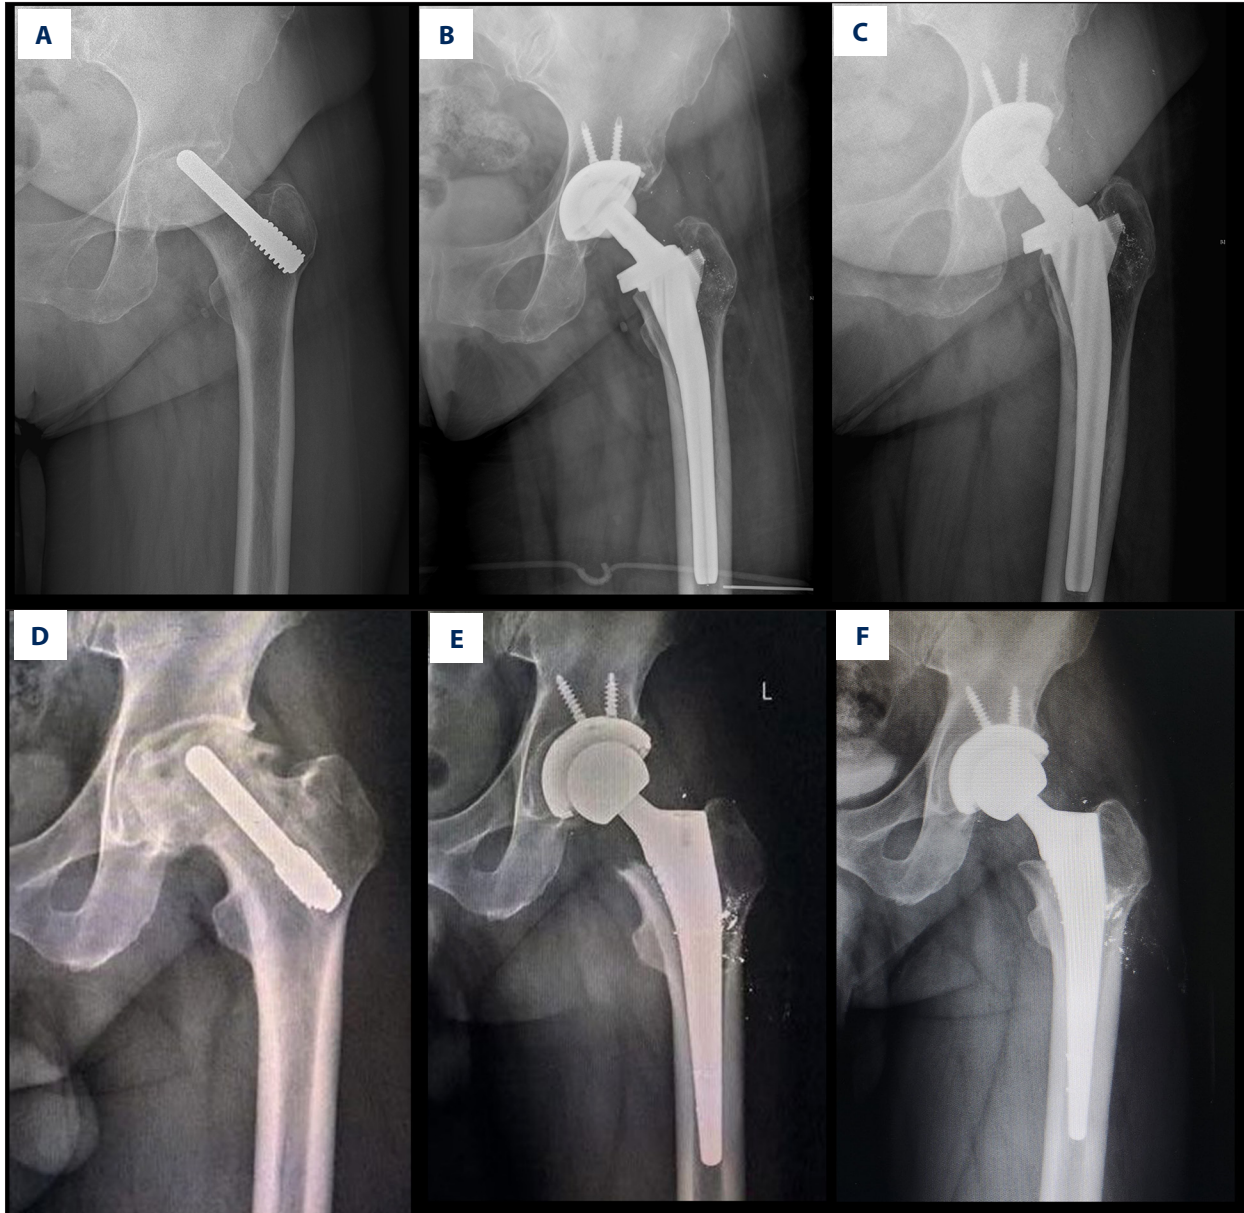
Tantalum debris after total hip arthroplasty (THA) between the 2 methods. (A) Pre-operative x-ray image; (B) x-ray image acquired 1 year after operation; (C) x-ray image obtained 5 years after operation on 67-year-old female using the antegrade procedure. (D) Pre-operative x-ray image; (E) x-ray image acquired 1 year after operation; (F) x-ray image obtained 5 years after operation on 46-year-old male using the retrograde procedure. There was more tantalum debris in retrograde procedure.
